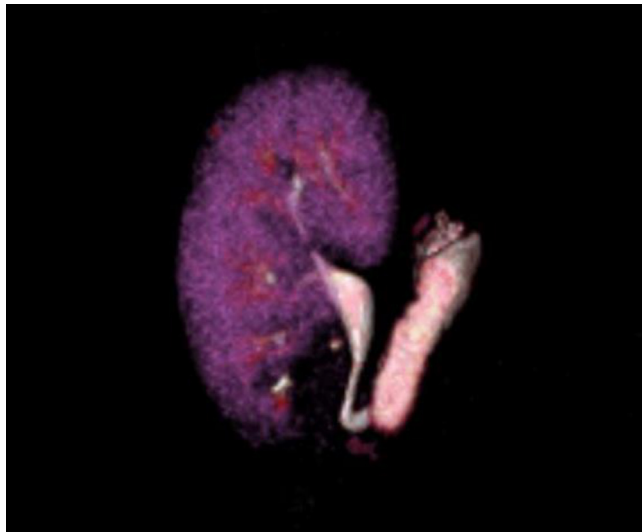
Computed tomography reconstruction of the kidney graft and ileal conduit.
